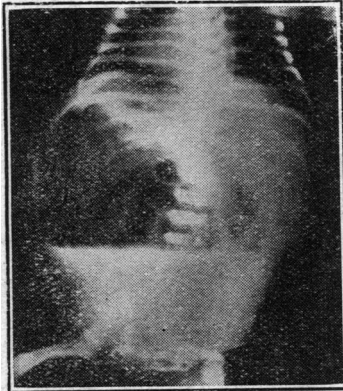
Case 2. Radiograph taken aged 6 days, showing a fluid level.
